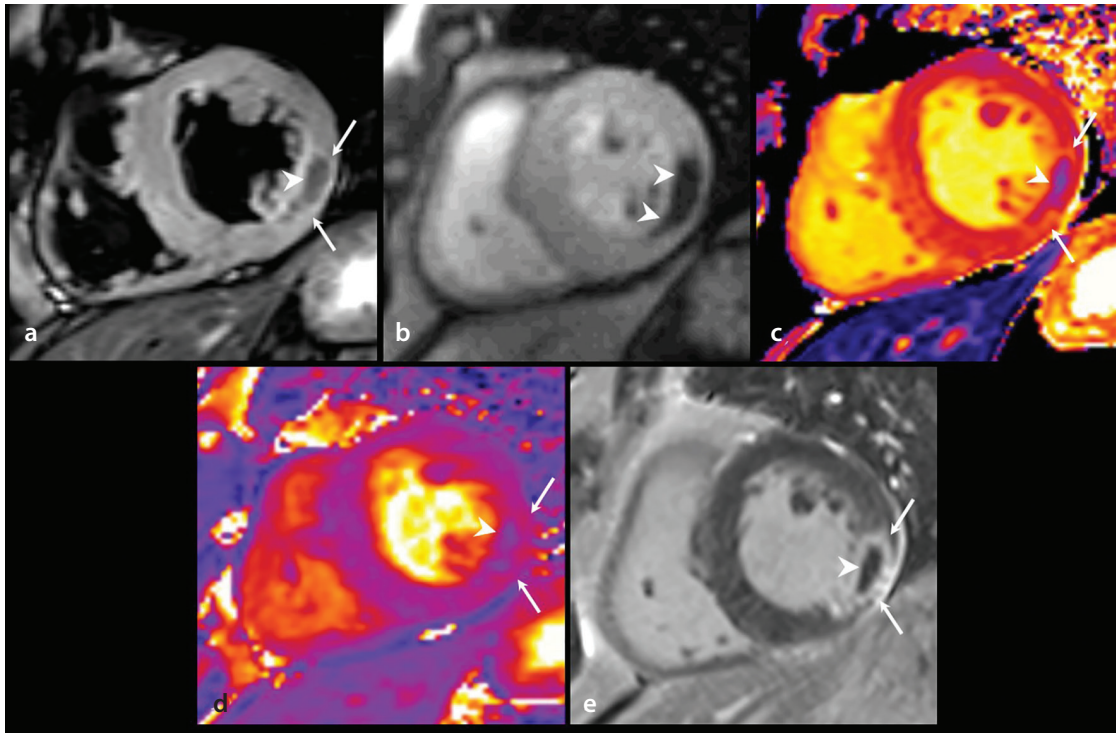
Evaluation of MVO in a 49-year-old man with reperfused STEMI using various CMR imaging techniques (a): Short-axis T2-weighted STIR image shows transmurally high signal intensity (arrows) and transmurally dark signal intensity (arrowhead) in the mid-inferolateral LV segment. (b): Short-axis first-pass perfusion image shows a transmurally perfusion defect (arrowheads) in the mid-inferolateral LV segment. (c, d): Short-axis T1 (c) and T2 mapping (d) images show elevated T1 (1,379–1,435 ms) and T2 (46–54 ms) values along the infarct border (arrows) and shortened T1 (1,093–1,127 ms, c) and T2 values (27–33 ms, d) in the infarct core (arrowheads). (e): Short-axis LGE image shows transmurally inferolateral infarction (arrows) with MVO in the infarct core (arrowhead). CMR, cardiac magnetic resonance; MVO, microvascular occlusion; STEMI, ST-segment elevation myocardial infarction; LV, left ventricular; LGE, late gadolinium enhancement; STIR, short tau inversion recovery.
